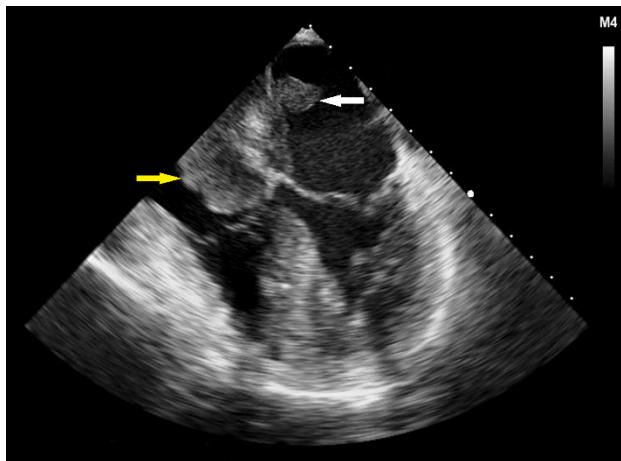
Transesophageal echocardiography demonstrating a large, cauliflower-shaped mass in the right atrium (yellow arrow) and a smaller mass in the left atrium (white arrow).
